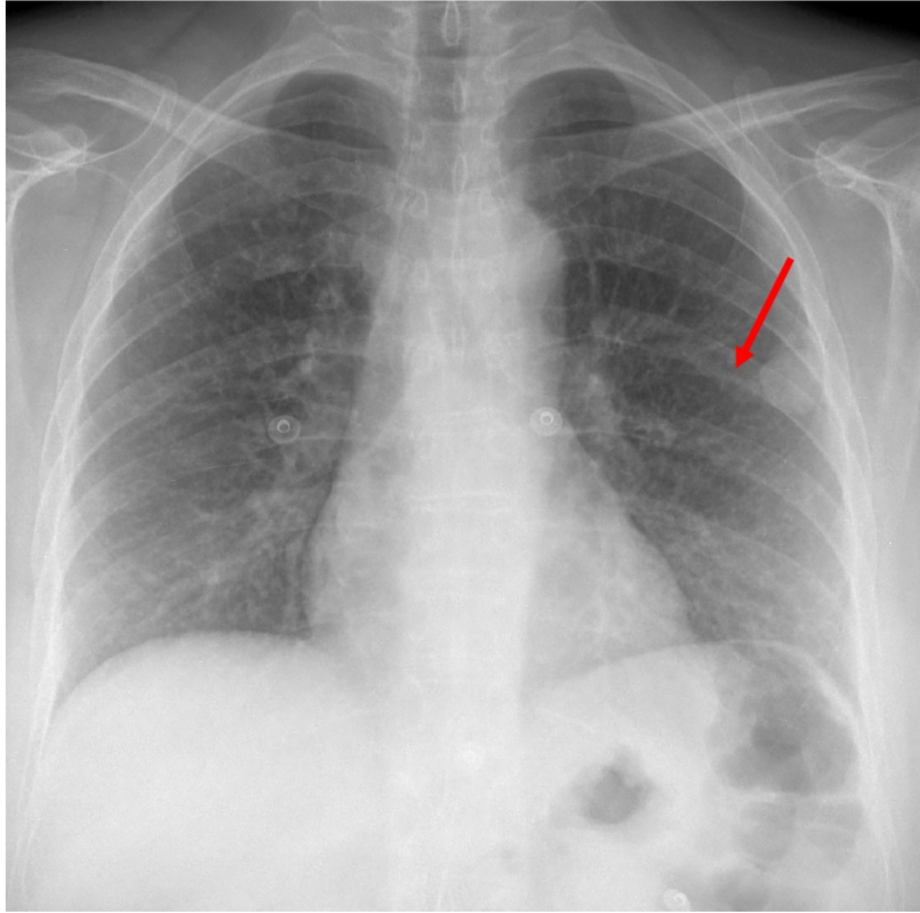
Images from a patient with a pulmonary arteriovenous malformation in the left upper lobe. PA chest radiograph shows a left mid peripheral nodule with a medial tubular opacity (→) that courses from the nodule to the hilum. CTA chest confirms the presence of a lobulated intensely enhancing nodule with feeding arterial and draining venous vessels.
